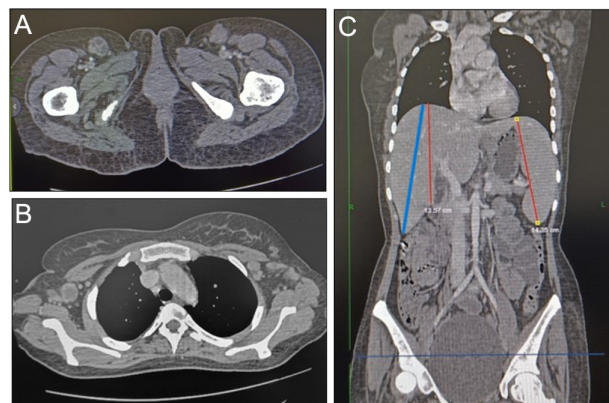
A: Axial section on contrast-enhanced computed tomography of the chest show bilateral enlarged necrotic axillary lymph nodes measuring 17 mm on the right and 20 mm on the left side; B: Bilateral inguinal necrotic lymph nodes are seen largest measuring 17 mm on the right side; C: Coronal section shows splenomegaly of 14 cm.
